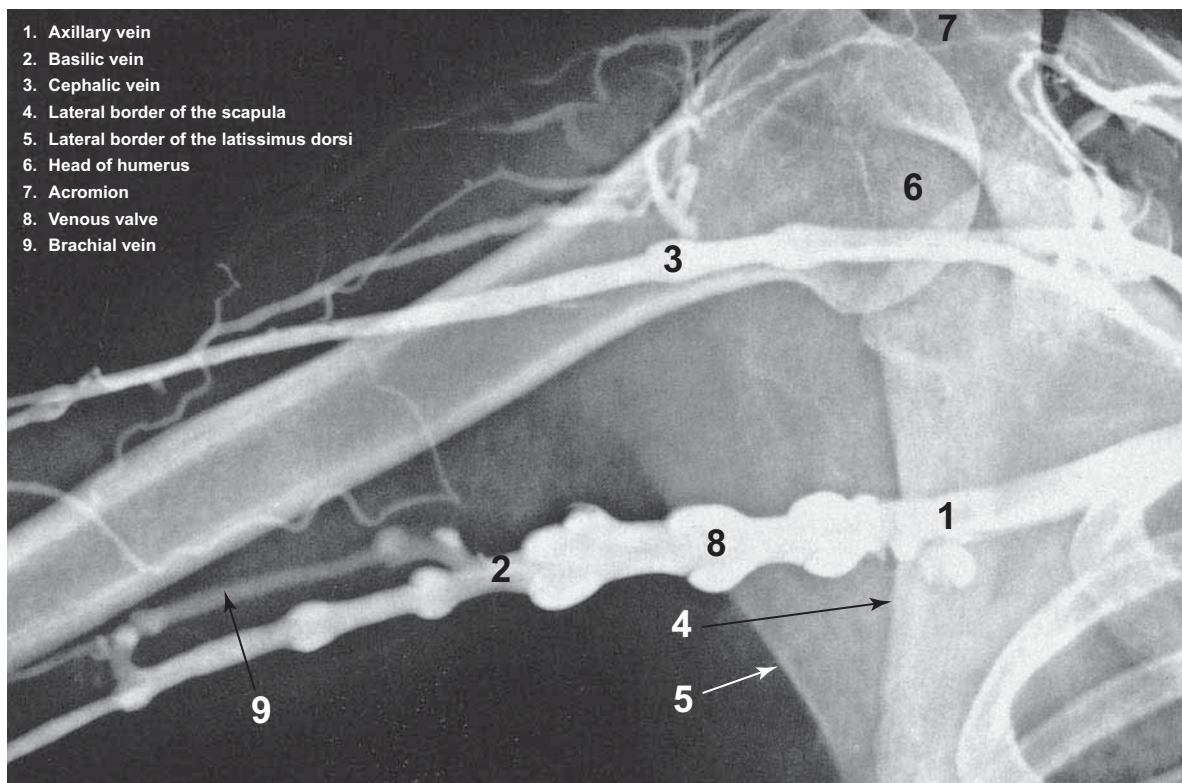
Radiograph of Veins in the Axillary Region
